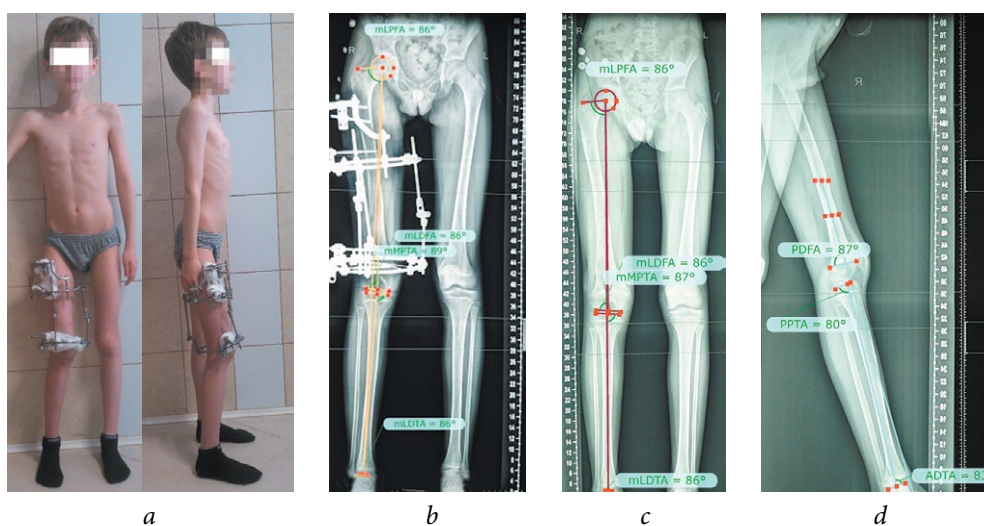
Patient G., 12 years old, with consequences of hematogenous osteomyelitis of the right hip. After treatment: *a* — appearance; *b* — panoramic radiograph before removal of the external fixation device; *c*, *d* — panoramic radiographs 1 year after treatment, the mechanical axes of the proximal and distal sections correspond to normal values
